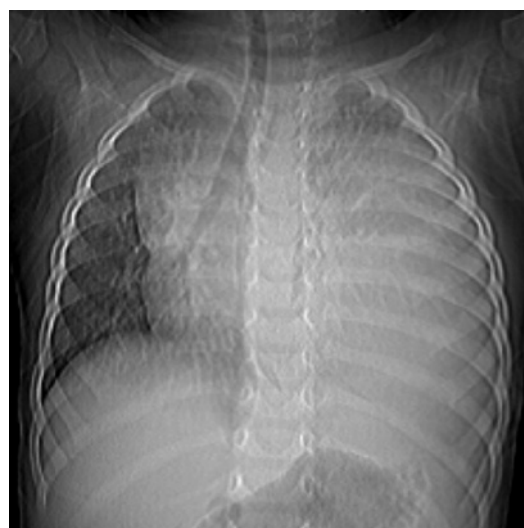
Chest x-ray showing opacification of the lower two-thirds of the left hemithorax. Part of the left upper lobe is still aerated.
